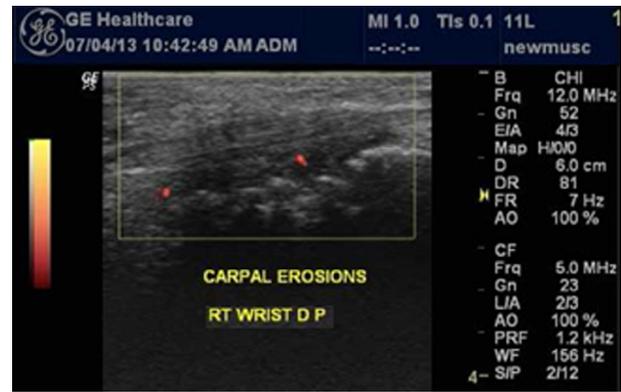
Ultrasonographic image showing carpal erosions in a patient with RA.
